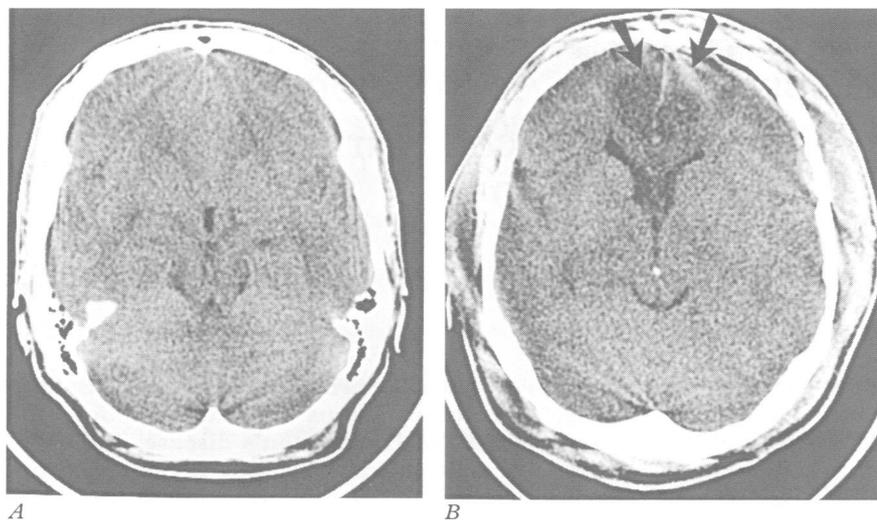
CT showing bilateral frontal hypodensities. (A) day 1; (B) day 3 (arrows).
